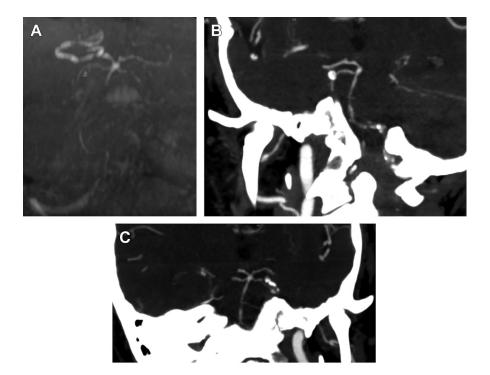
(*A*) MRA of the head without contrast showing slow/absent flow in the basilar artery. (*B*) Computed tomography angiography (CTA) of the head, sagittal projection images, showing severe atherosclerosis in the left vertebral and mid–basilar artery. (*C*) Coronal CTA of the head showing severe midbasilar stenosis.
